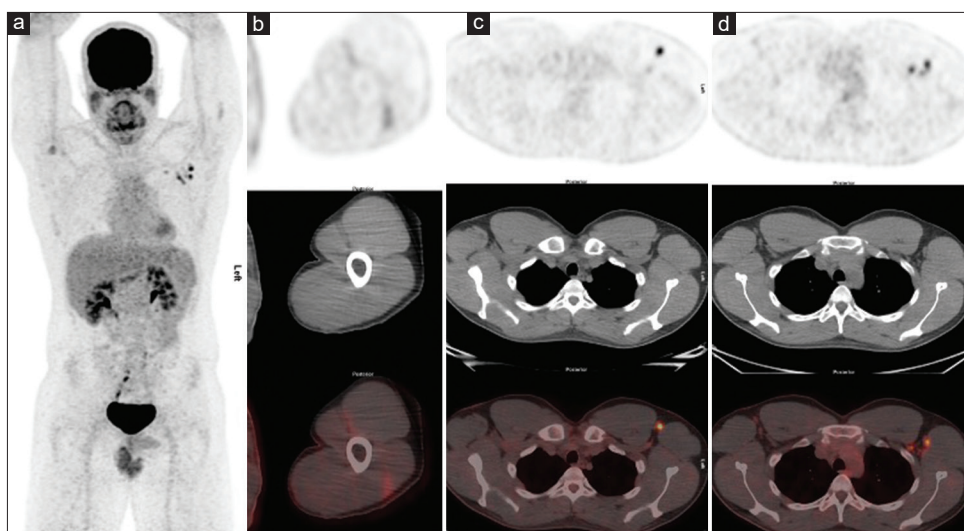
a) Interim <sup>18</sup>F-FDG PET MIP image demonstrate complete metabolic response of prior hypermetabolic bilateral supraclavicular and mediastinal lymph nodes. Although multiple new hypermetabolic left axillary and subpectoral lymph nodes are noted. Non-contrast CT images show normal lymph nodes (c,d). Relevant history revealed COVID vaccine 7 days prior scan with mild FDG uptake at left deltoid muscle (b). These new findings at left axilla are likely related to recent vaccination
